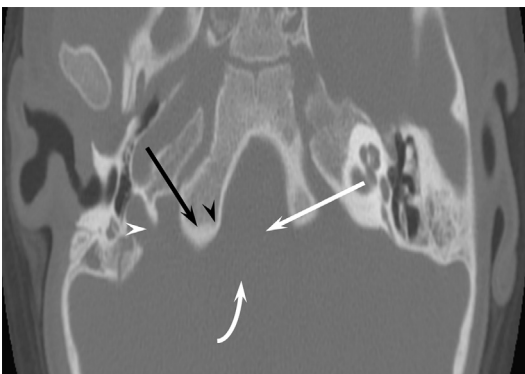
Arnold nerve. Axial CT with several adjoining anatomic structures labeled. White arrow, minor contour irregularity along pars vascularis of jugular foramen at the expected site of mastoid canaliculus; white arrowhead, tympanomastoid suture along posterior wall of external auditory canal, carrying Arnold nerve; black arrowhead, vertical/mastoid segment of facial nerve canal; curved arrow, anterior portion of occipitomastoid suture (unfused because the patient is a child); black arrow, chorda tympani.
